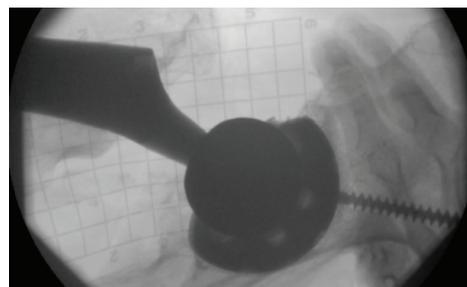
With X-Grid, a point in the hip socket was localized with a single fluoroscopic X-ray.
